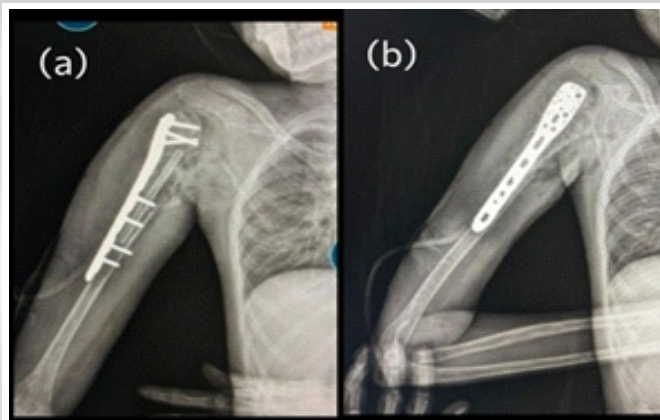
Post-operative radiograph. (a) Anteroposterior view (b) lateral view.
